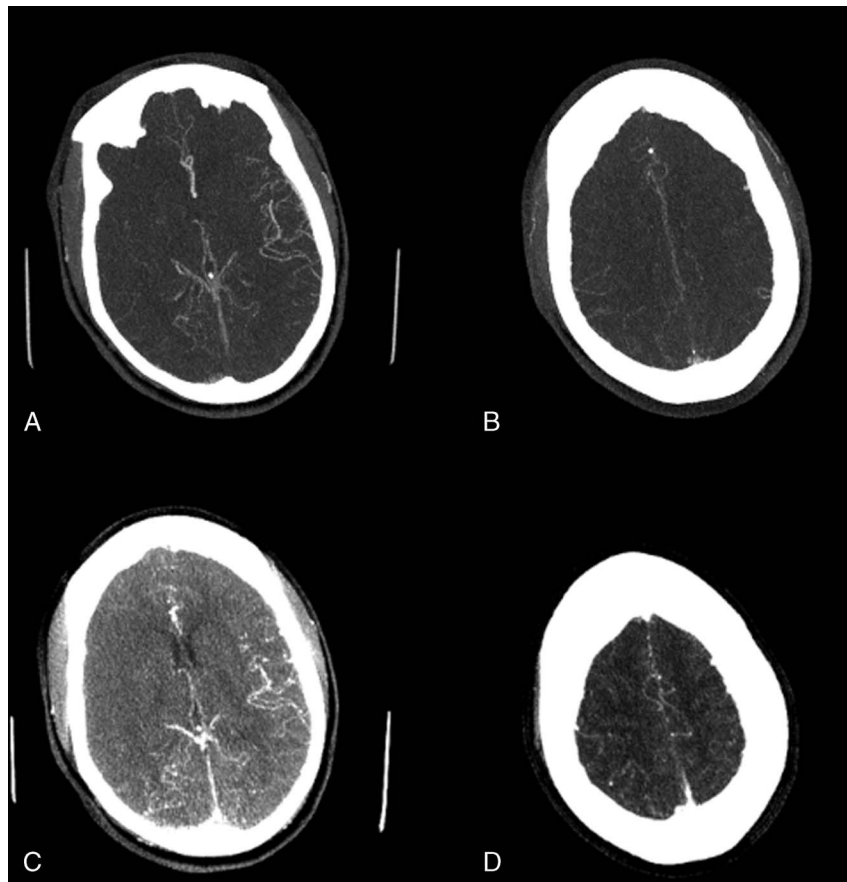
Example case with collateral circulation graded as poor by the 2 observers. Single-phase CTA images are shown on ASPECTS levels 1 (A) and 2 (B). Three-phase CTA images were created from PCT source data. The first phase of the 3-phase CTA images is shown on ASPECTS levels 1 (C) and 2 (D).
